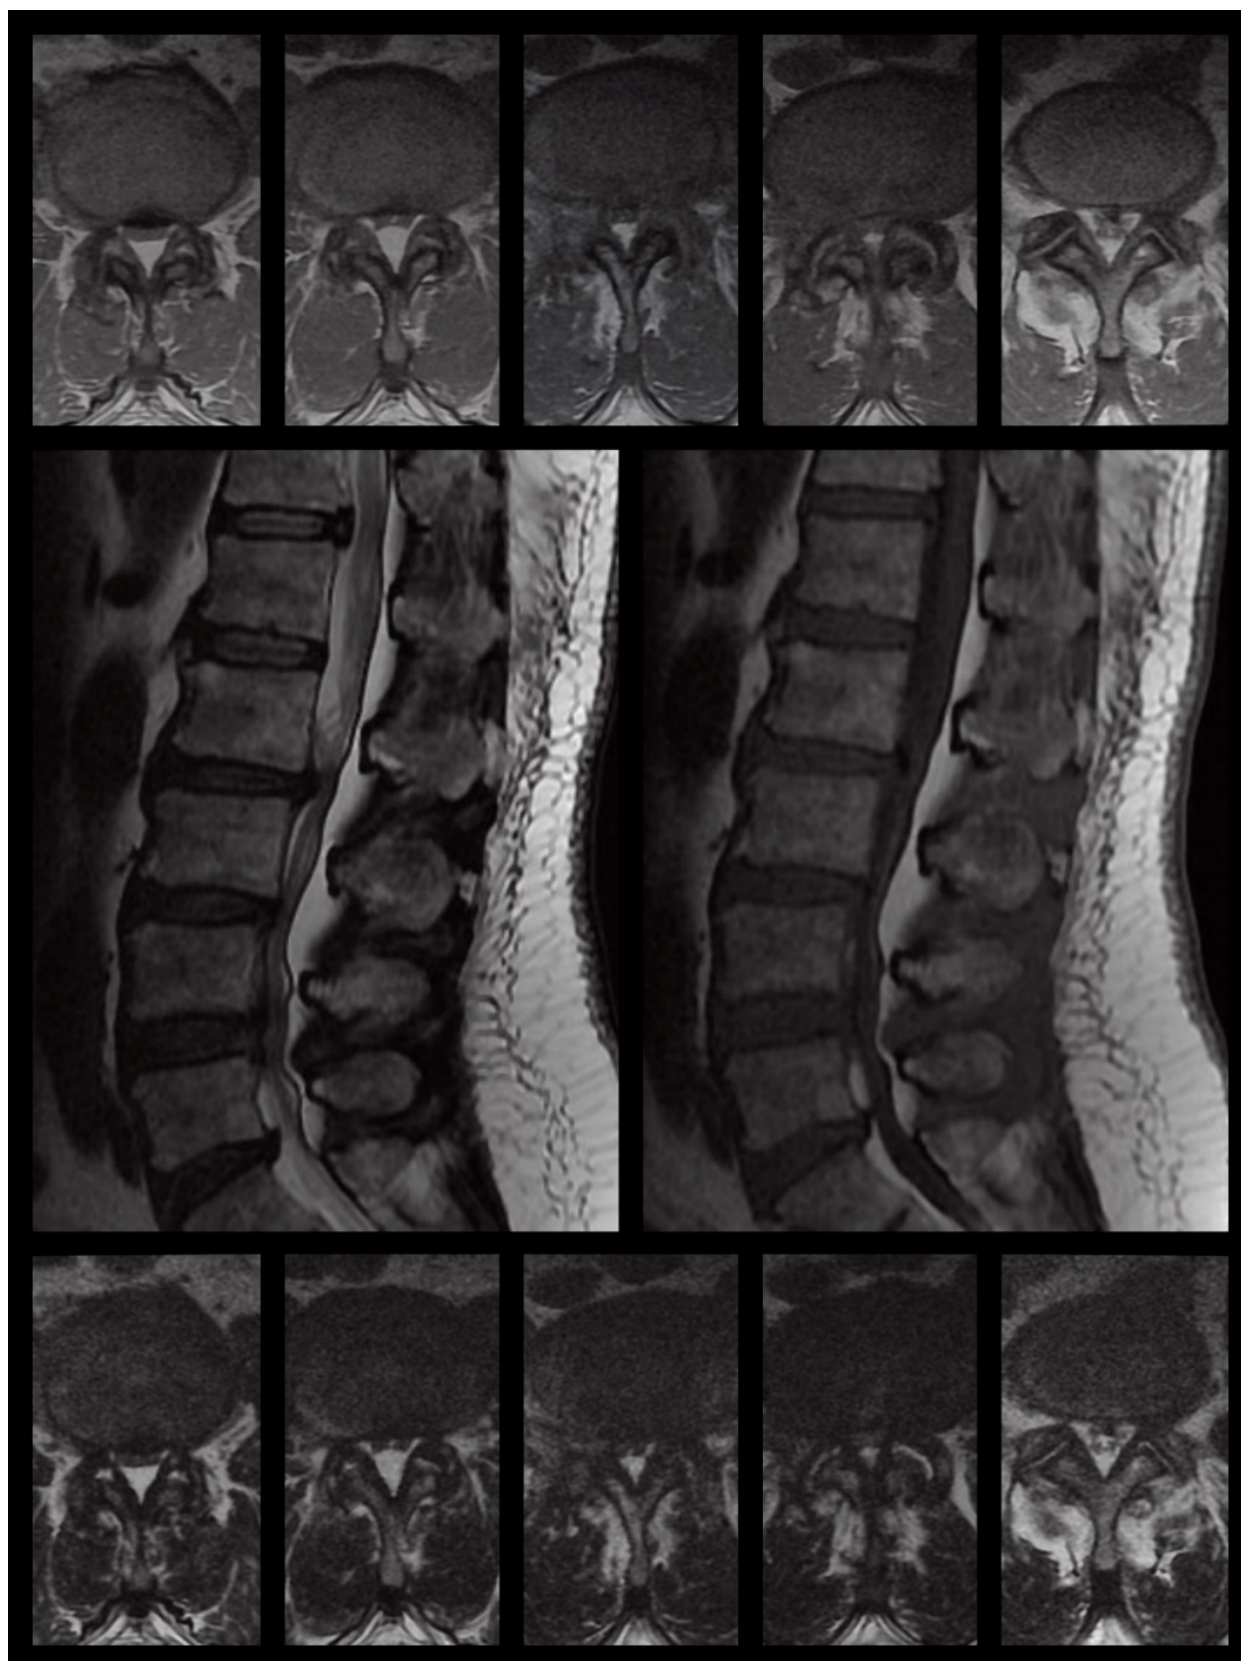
Preoperative MRI images
